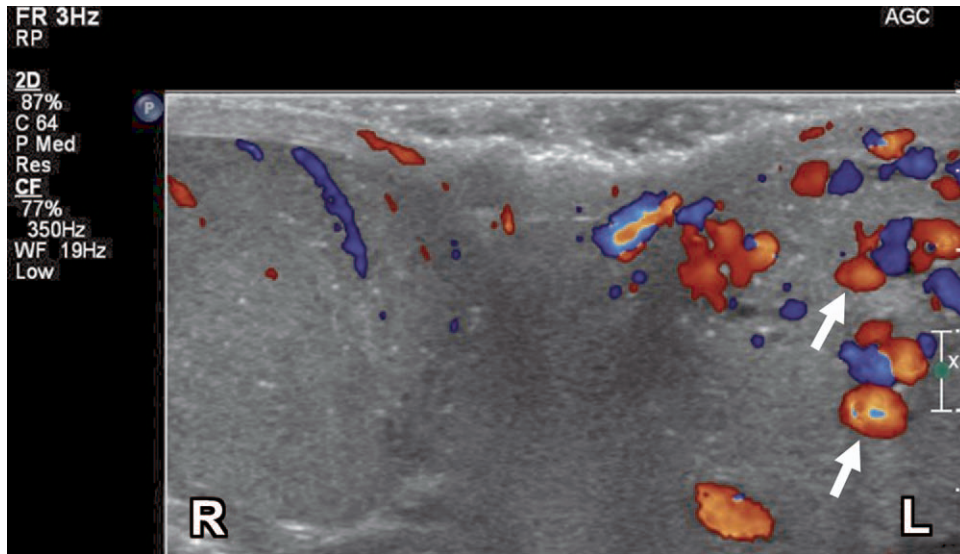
Transverse color Doppler sonogram of both testes demonstrates spontaneous flow within the larger left anechoic tubular structures (arrows), consistent with intratesticular varicocele.
